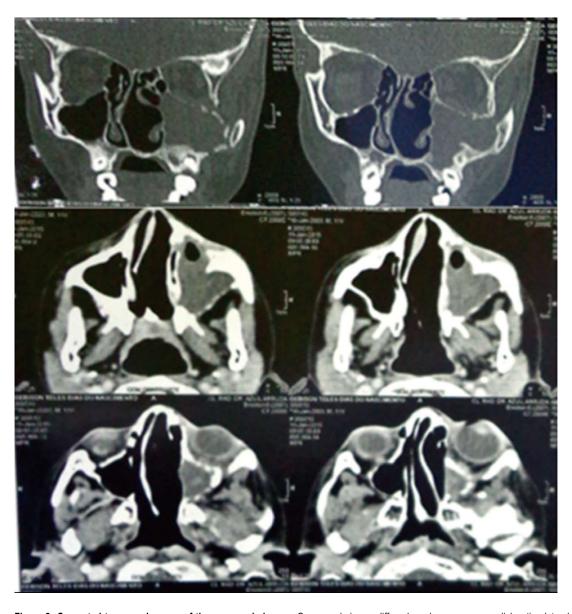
Computed tomography scan of the paranasal sinuses. On coronal view, a diffuse hypodense mass was dislocating lateral wall of left sinus and compressing the inferior border of left orbital structure with tumor invasion. On axial plan, tumor mass was filling the left sinus and a dislocated nasal septum was evident.
